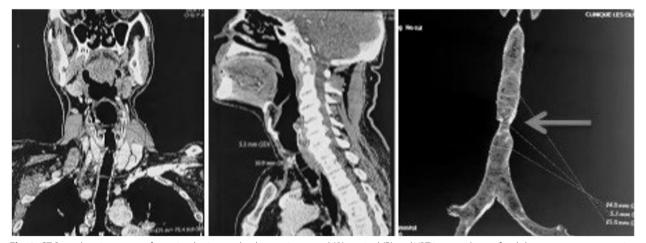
CT Scan showing a case of post-intubation tracheal stenosis: coronal (A), sagittal (B) and VRT images show a focal short segment concentric narrowing of the tracheal wall giving an "hourglass" configuration (arrow)
